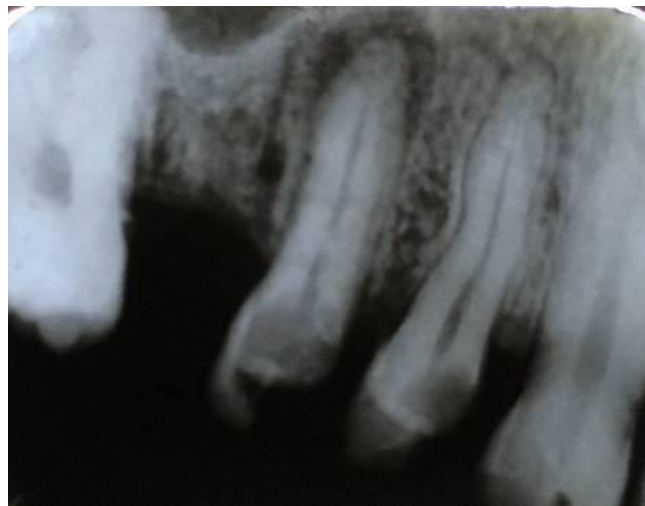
Radiografia periapical *ante-mortem*.
